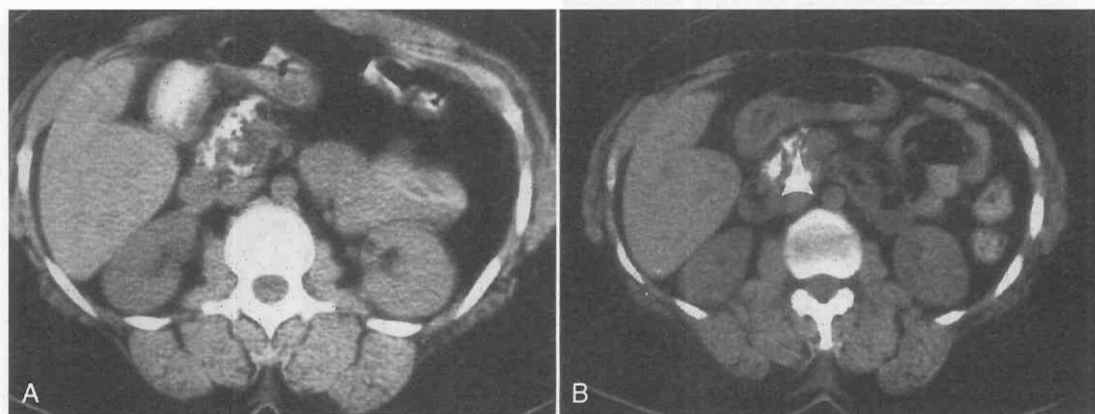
A, Decalcification can occur rarely. This early CT scan shows dense calcium deposits within the head. B, Later scan demonstrates that the overall size of the gland has not changed but the density of the anterior calcification (arrowhead) has decreased owing to decalcification.
